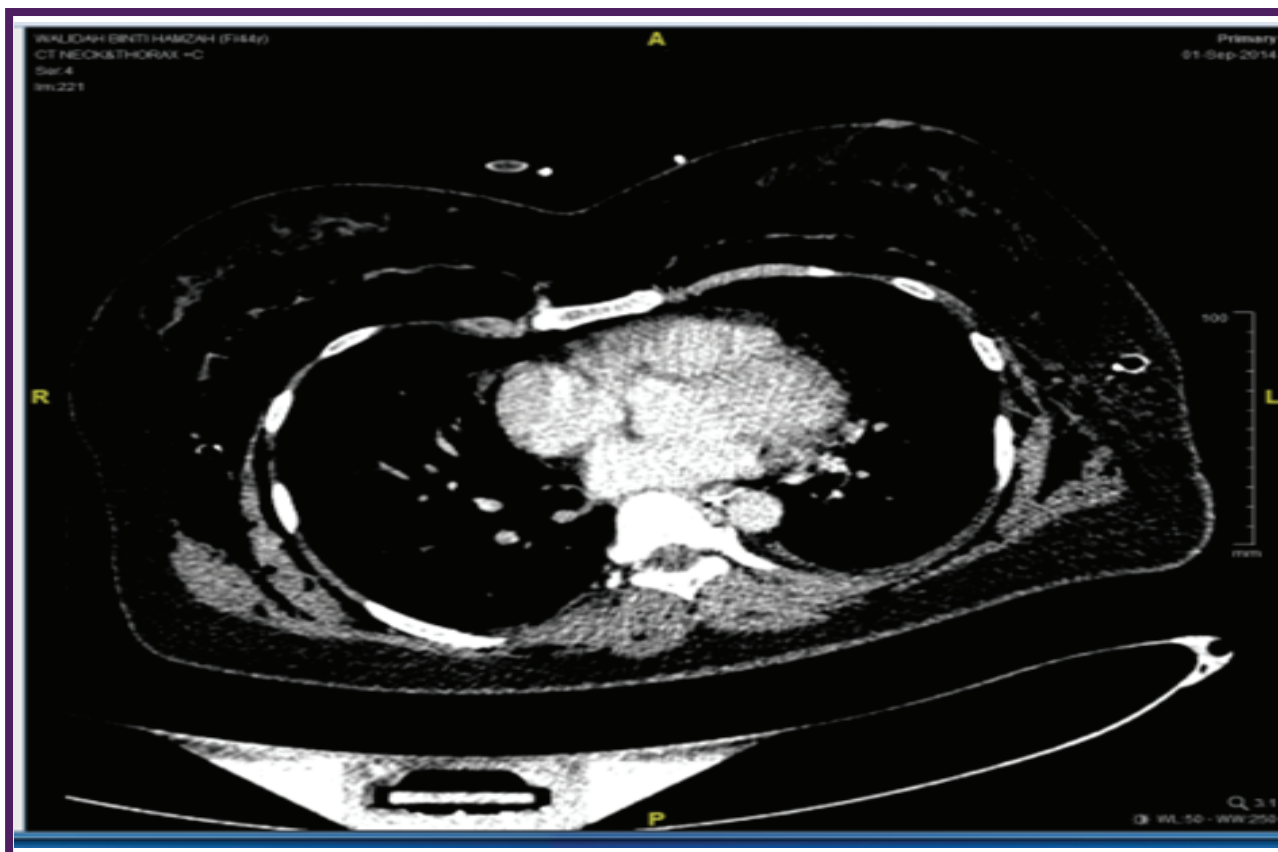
CT. Neck, chest, and abdomen requested after stabilizing the patient, it shows, break in the posterior part of the trachea at level T4 with posterior air tract indicate tracheal injury, massive surgical emphysema from the neck up to the upper abdominal wall, bilateral pneumothorax, pneumo-mediastinum, and pneumo- pericardium.
